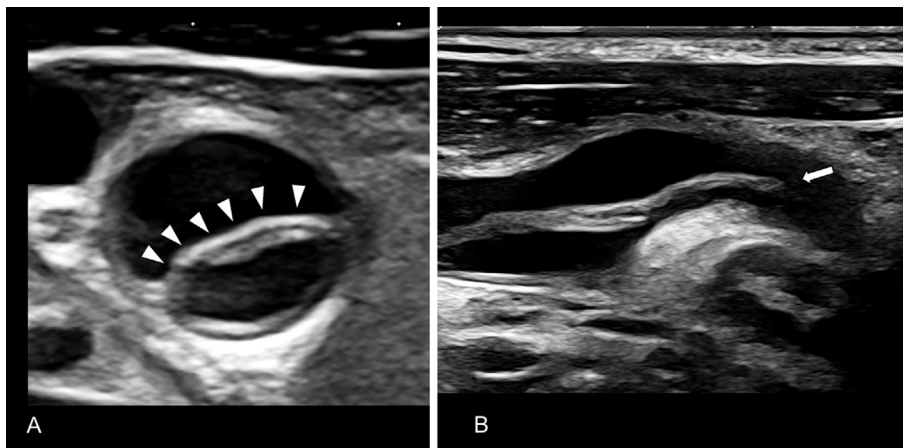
Carotid ultrasonography of the right CCA to the extracranial ICA. A) Axial B mode image showing an intimal flap in the right CCA (arrowheads). B) Longitudinal B mode image showing the false lumen communicating with the true lumen at the immediately proximal segment of the internal carotid artery (arrow). CCA: common carotid artery, ICA: internal carotid artery
